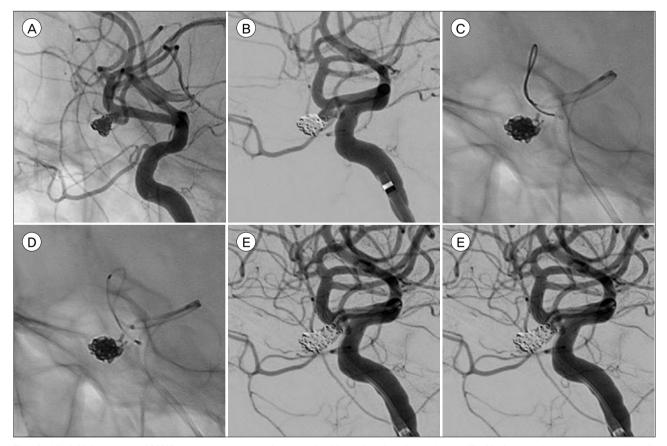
(A) Initial ruptured MCBIF aneurysm completely treated with a double microcatheter. (B) Neck growth seen as an undertalland overwide-neck aneurysm with vessel branches 2 years after the initial treatment. (C) The delivery microcatheter is looped from the inferior to the superior trunk of the MCA. (D) A Neuroform Atlas stent placed directly over the looping segment with control of tension. (E) Complete stent-assisted coil embolization. (F) The Vaso-CT image that confirmed the stenting. MCBIF = middle cerebral bifurcation; MCA = middle cerebral artery; CT = computed tomography.
